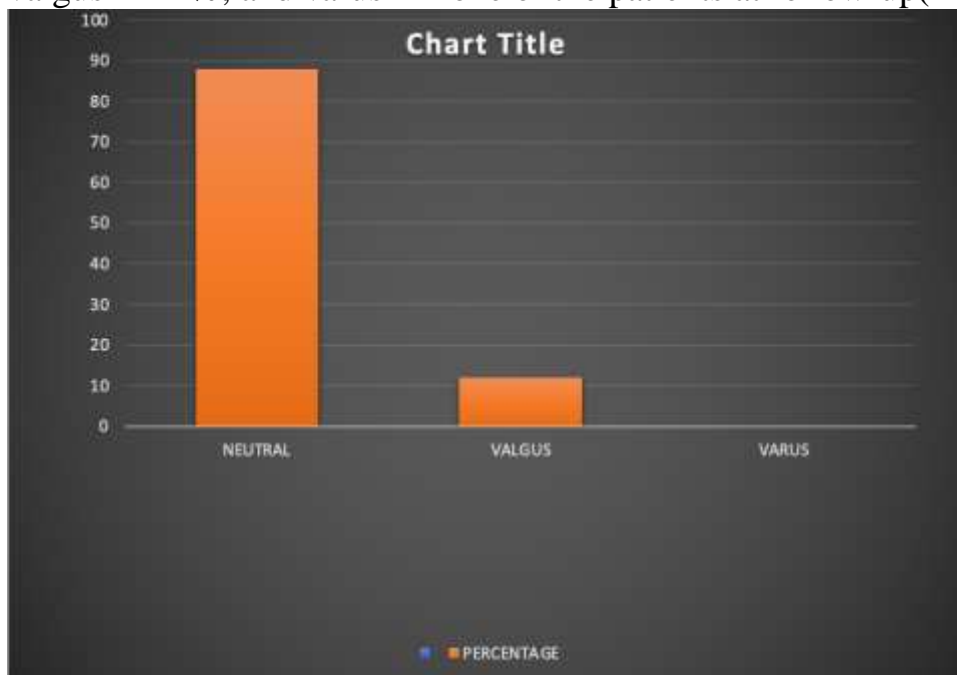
showing femoral component on radiography
